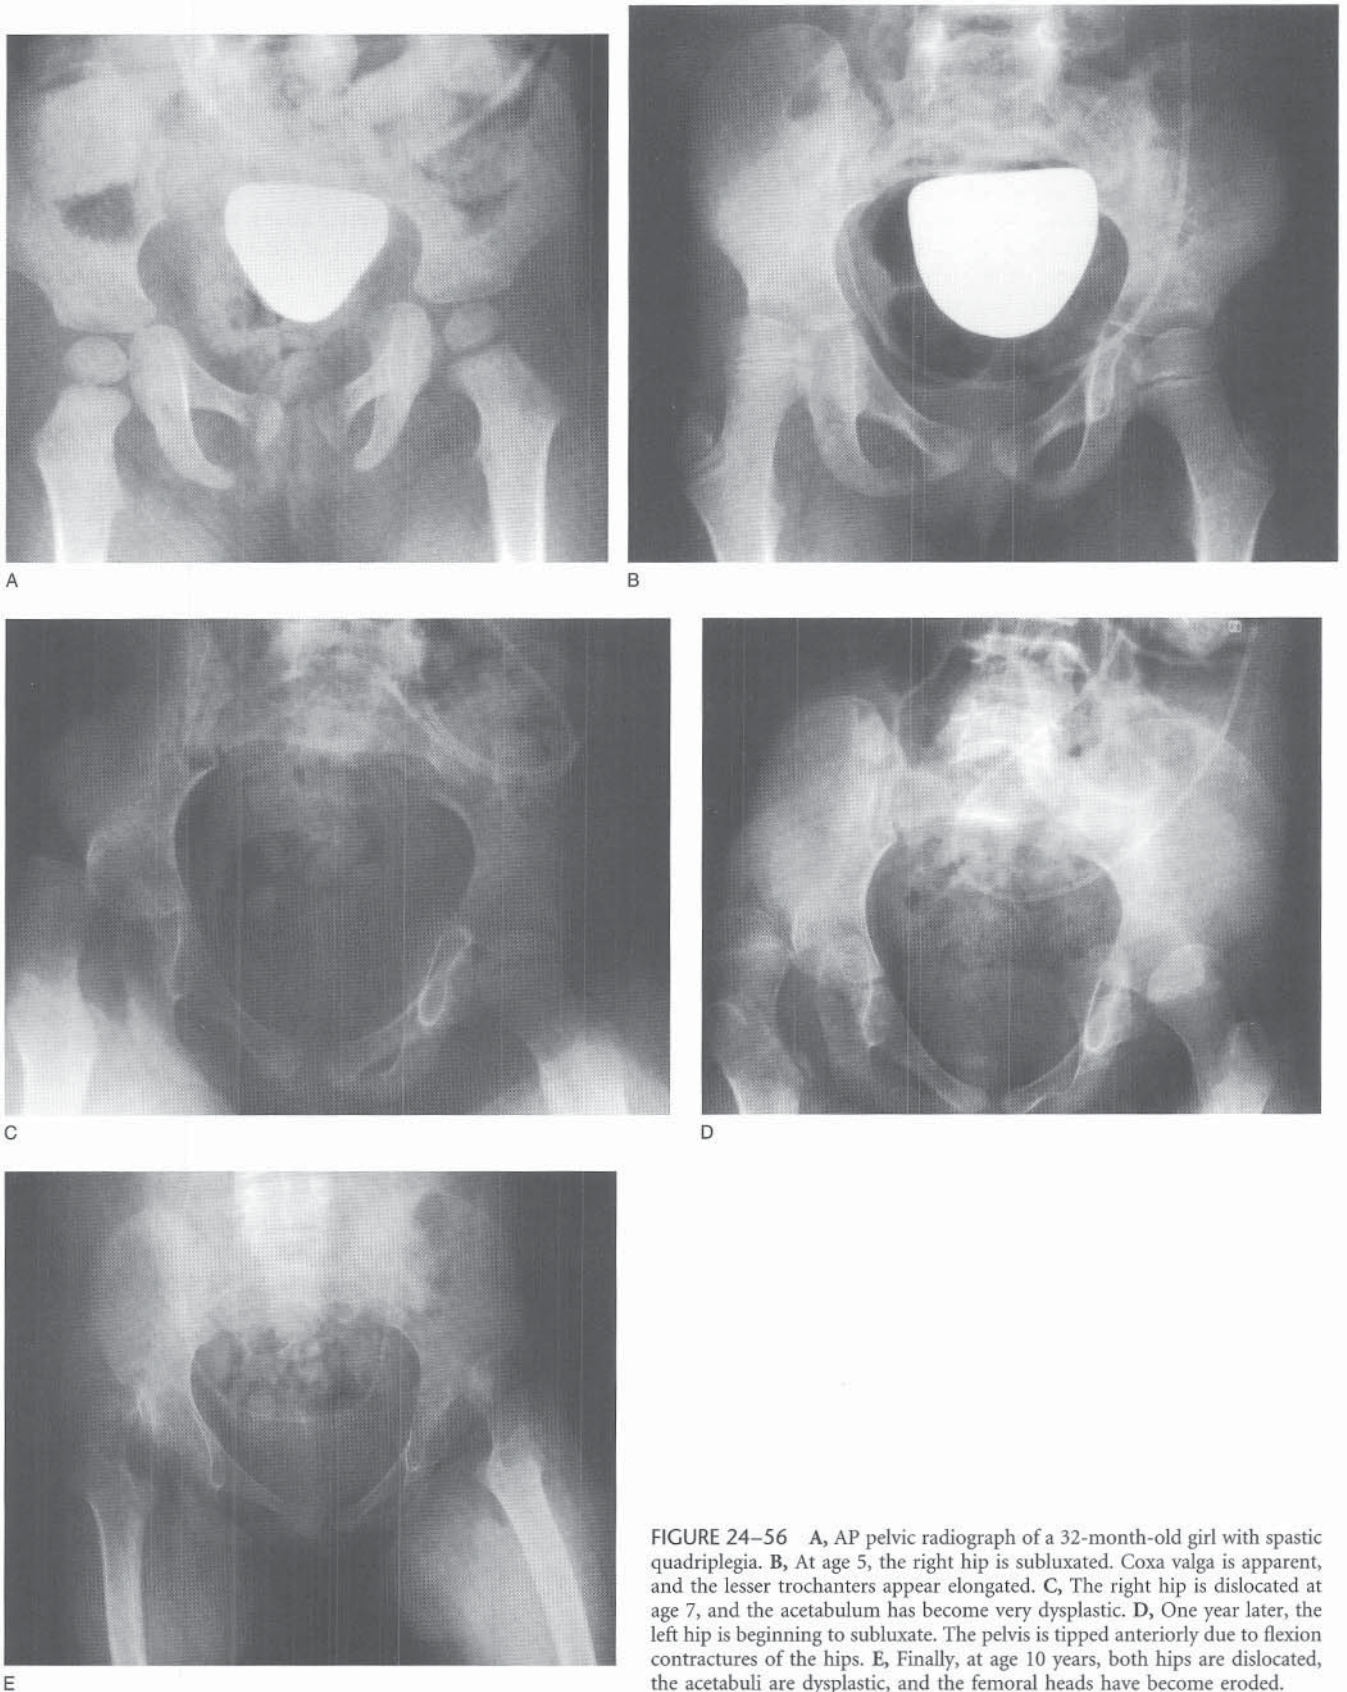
A, AP pelvic radiograph of a 32-month-old girl with spastic quadriplegia. B, At age 5, the right hip is subluxated. Coxa valga is apparent, and the lesser trochanters appear elongated. C, The right hip is dislocated at age 7, and the acetabulum has become very dysplastic. D, One year later, the left hip is beginning to subluxate. The pelvis is tipped anteriorly due to flexion contractures of the hips. E, Finally, at age 10 years, both hips are dislocated, the acetabuli are dysplastic, and the femoral heads have become eroded.
